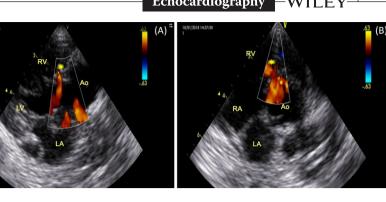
Intraoperative epicardial echocardiogram of a patient with tetralogy of Fallot (10 mo old). A, modified short-axis view, color flow shows free pulmonary regurgitation; B, modified short-axis view; C, modified long-axis view: D. modified view of interatrial septum. Ao = aorta; IAS = interatrial septum; LA = left atrium; LPA = left pulmonary artery; LV = left ventricle, MPA = main pulmonary artery; RA = right atrium; RPA = right pulmonary artery; RV = right ventricle; RVOT = right ventricular outflow tract. Arrow shows interatrial communication, \* shows ventricular septal defect (VSD) patch
